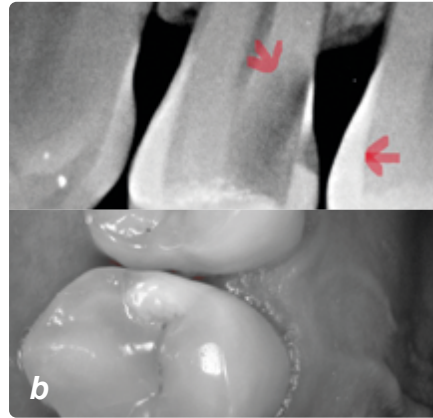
b: X-ray bitewing and C50 Cario mode
